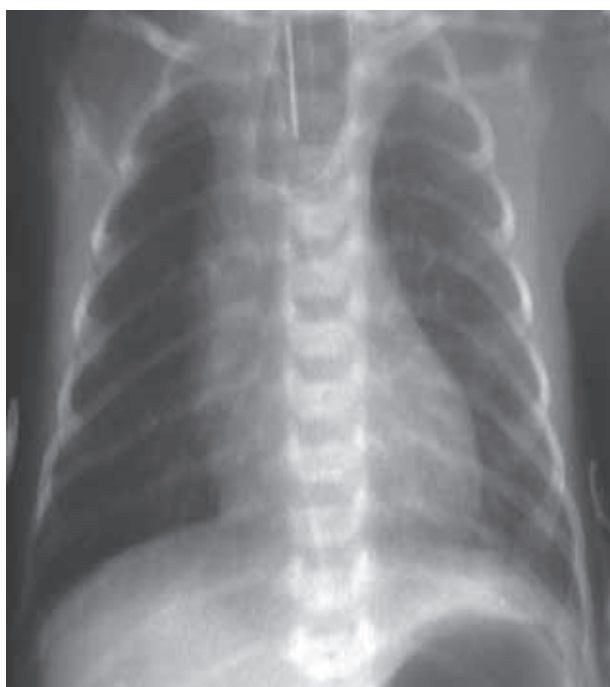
X-ray of Esophageal atresia (with nasogastral tube)
